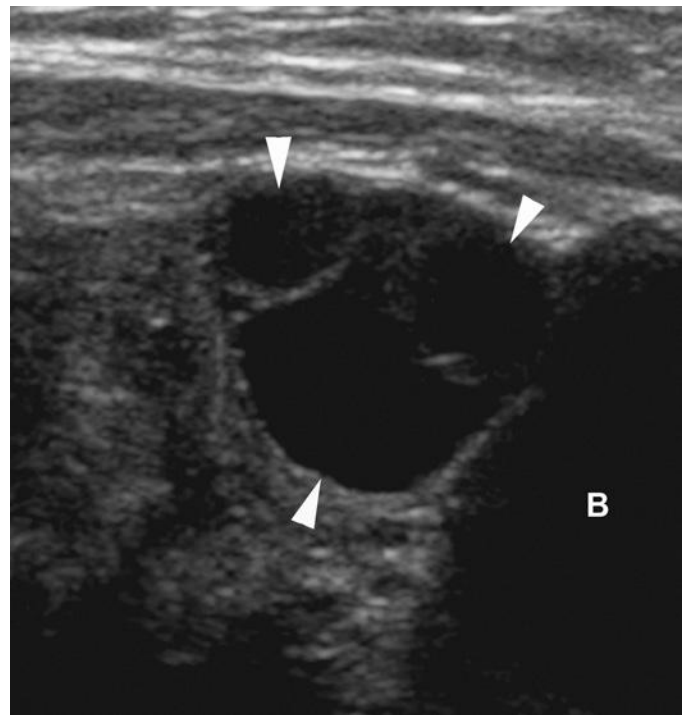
Normal neonatal ovary. Sagittal ultrasound image demonstrates multiple anechoic follicles (arrowheads). B, bladder.
